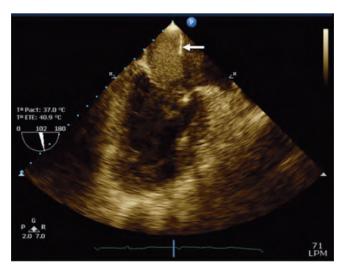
Echocardiographic study showing the mass (arrow) in the left atrium
